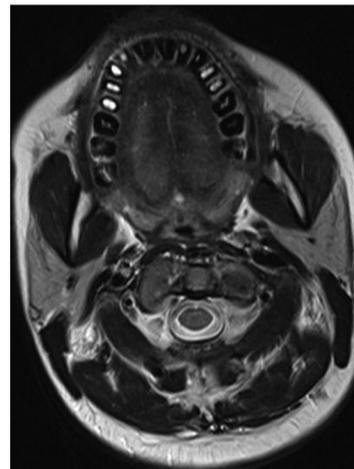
MRI (axial view) showing hyperintense areas within pulp chamber in T2 weighted images
